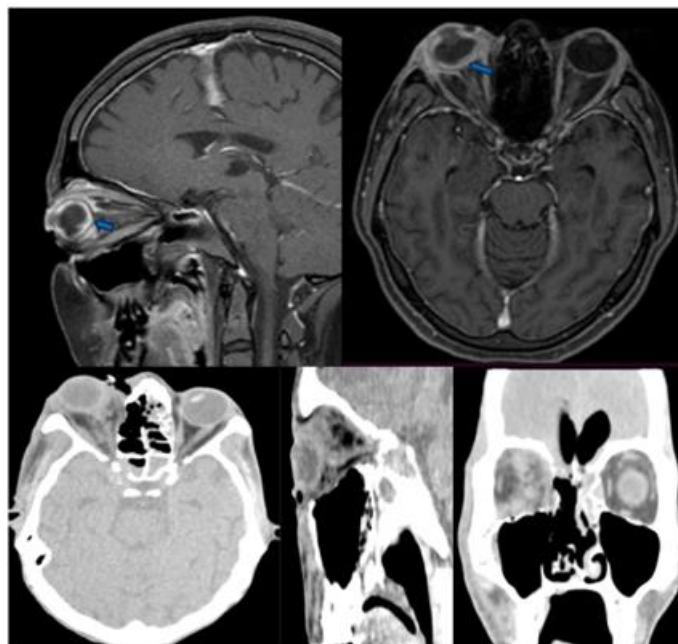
Plain CT and MR image showing diffuse scleral thickening (blue arrows) and bulky extraocular muscles with intraconal fat stranding on right side
